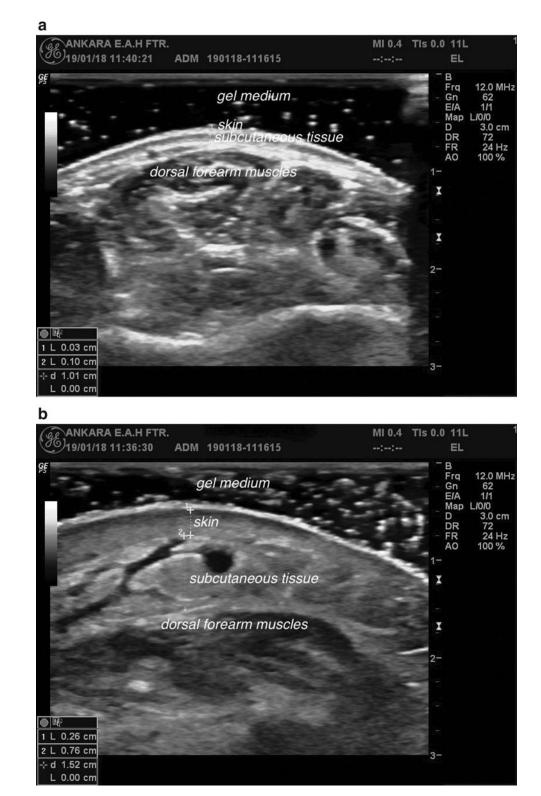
(a,b) The US images in skin and subcutaneous tissue of affected and normal dorsal forearm (with written permision of patient). US, ultrasonography
